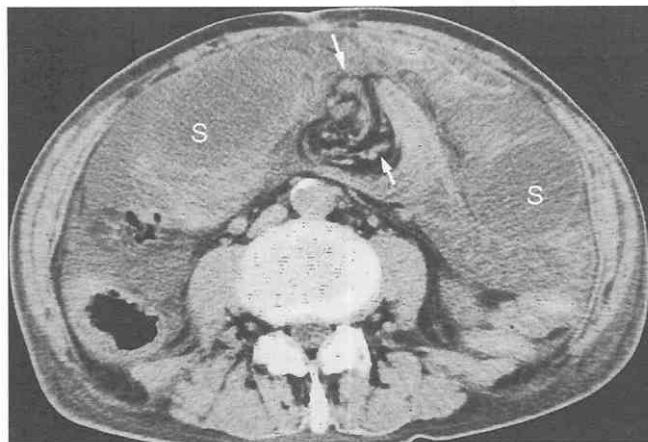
Closed-loop obstruction due to volvulus. CT scan shows twisting and engorgement of the mesenteric vessels ("whirl sign") (arrows) adjacent to the obstructed site. Note diffuse dilatation of the small intestine (S) and intraperitoneal fluid collection (asterisks). At surgery, strangulation was present in the involved segment. (From Ha HK, Rha SE, Kim JH, et al: CT diagnosis of strangulation in patients with small bowel obstruction: Current status and future direction. *Emerg Radiol* 2: 47-55, 2000.)
